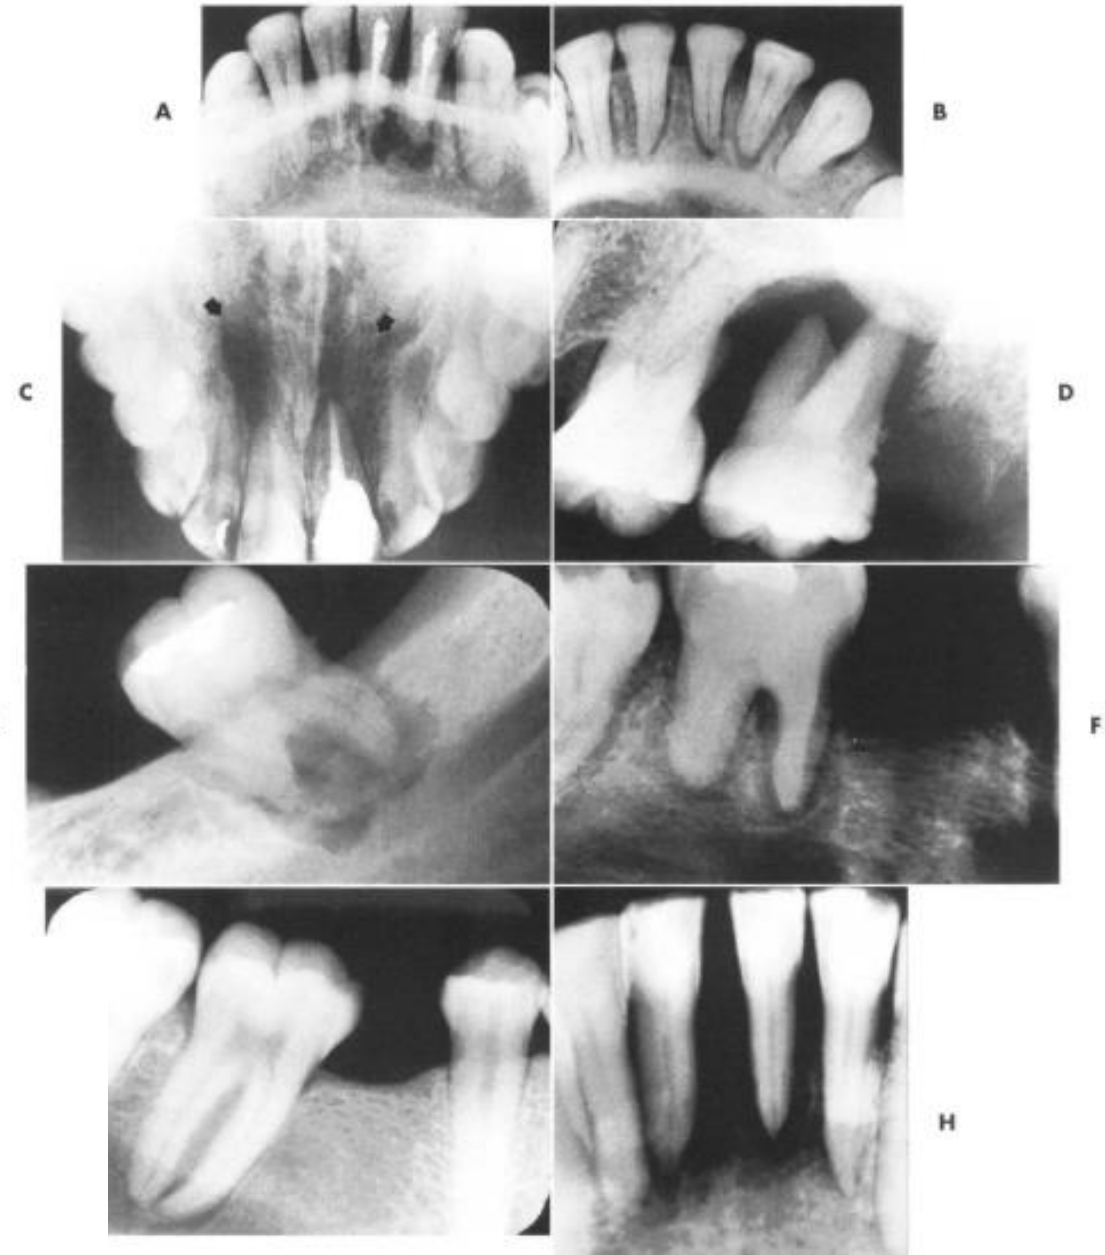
Malignant periapical radiolucencies. A, Chondrosarcoma. B and C, Osteogenic sarcoma. (The bandlike widening of the periodontal ligament spaces around the incisor roots is evident in B.) D, Adenoid cystic carcinoma on the posterolateral hard palate. E, Metastatic carcinoma from the pancreas. F, Hemangiosarcoma. The radiolucencies at the apices of the molar and the bandlike widening of the periodontal ligament spaces are evident on all teeth shown. G, Metastatic rhabdomyosarcoma at the periapex of a molar. H, Metastatic carcinoma at the apices of the central incisors. (A courtesy O.H. Stuteville, deceased; B and G courtesy R. Goepp, Chicago; C from Curtis M. Elmore J. Sotereanos G: Osteosarcoma of the jaws: report of a case and review of the literature, *J Oral Surg* 32:125-130, 1974; F courtesy D. Skuble, Hinsdale, Ill; H courtesy R. Oglesby, Stroudsburg, Pa.)
